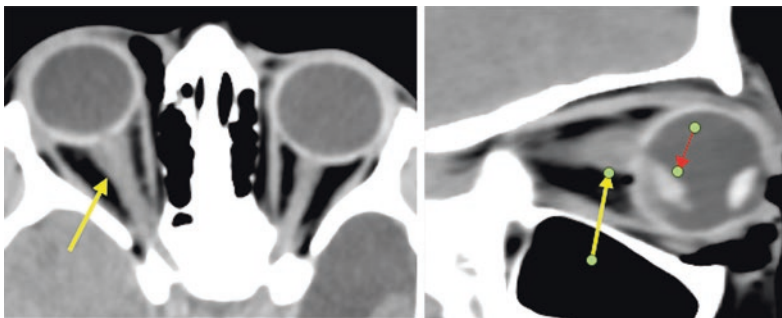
Traumatic optic neuropathy on CT. a–b Axial and sagittal reformatted non-contrast CT images demonstrate diffusely swollen right optic nerve yet preserving its continuity, impressive of optic nerve injury (long arrow). There are associated right sub-retinal/intraocular vitreous hemorrhage (short arrow) as well as minimal blurring of the retro-orbital fat, mild proptosis of the eye globe with intraorbital and eye lids emphysema
